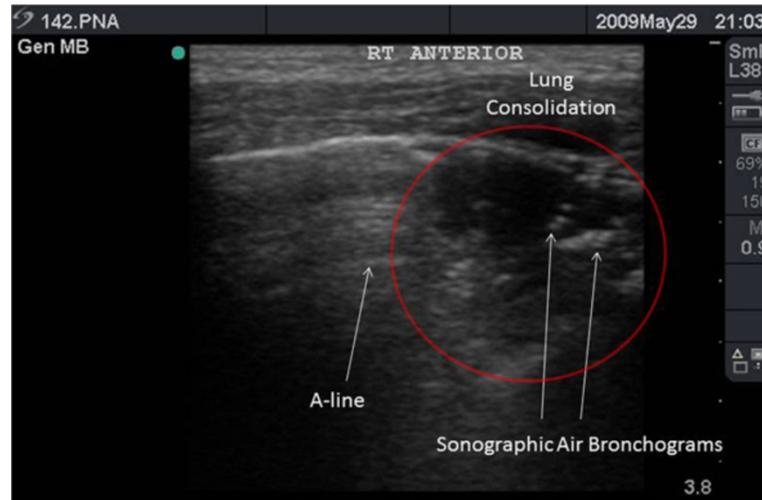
Lung consolidation with sonographic air bronchograms consistent with bacterial pneumonia.
